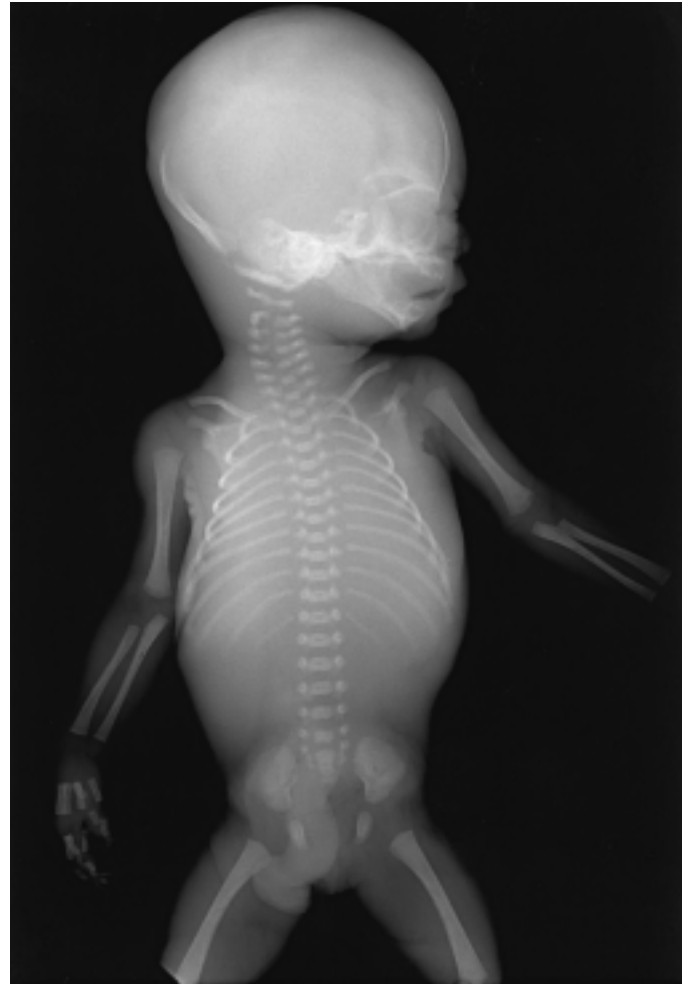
A typical fetal radiograph.
